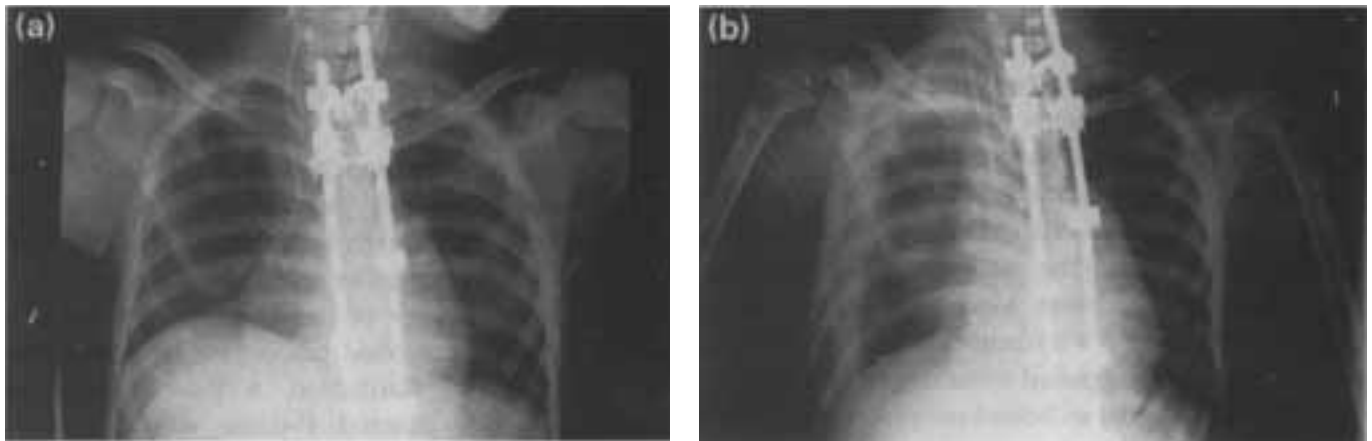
Chest x-ray image of a children with central venous catheter. a) On first image tip position was erroneously diagnosed as correct. b) Second image at a later time shows pleural effusion on right side due to misplaced catheter.
